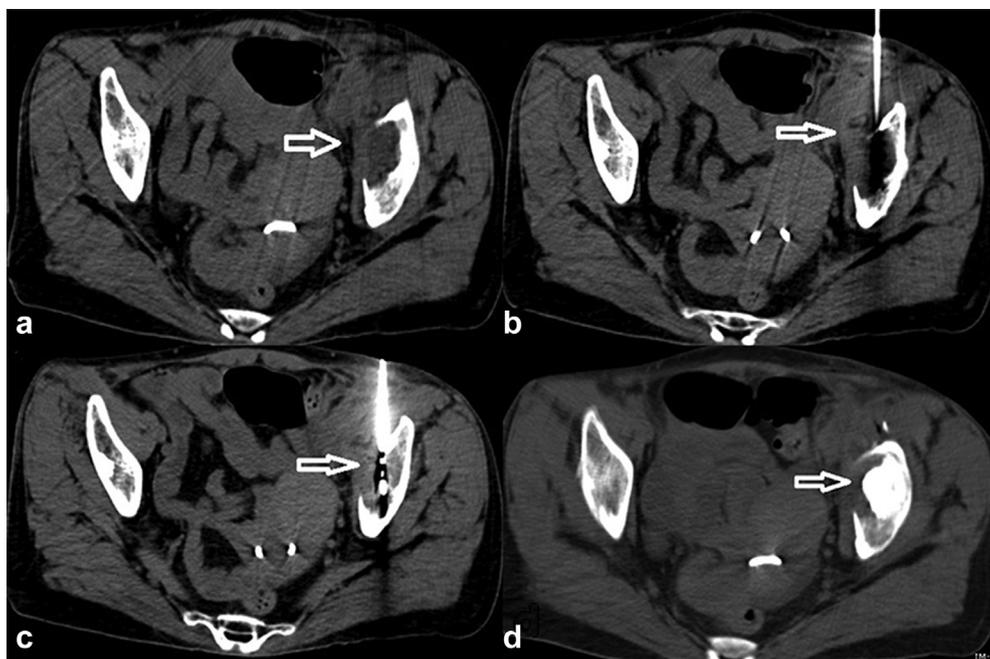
The procedure of MW ablation plus POP for a 62-year-old female with osteolytic metastases (arrow) in the left acetabular. (a) Metastatic lesion (arrow) in the left acetabular (CT scan). (b, c) Radiographs obtained during percutaneous puncture (arrow, b) and MW ablation (arrow, c). (d) After osteoplasty, homogeneous and sufficiently distributed bone cement (arrow) in the lesion location is shown. No evidence of bone cement extravasation was observed.
